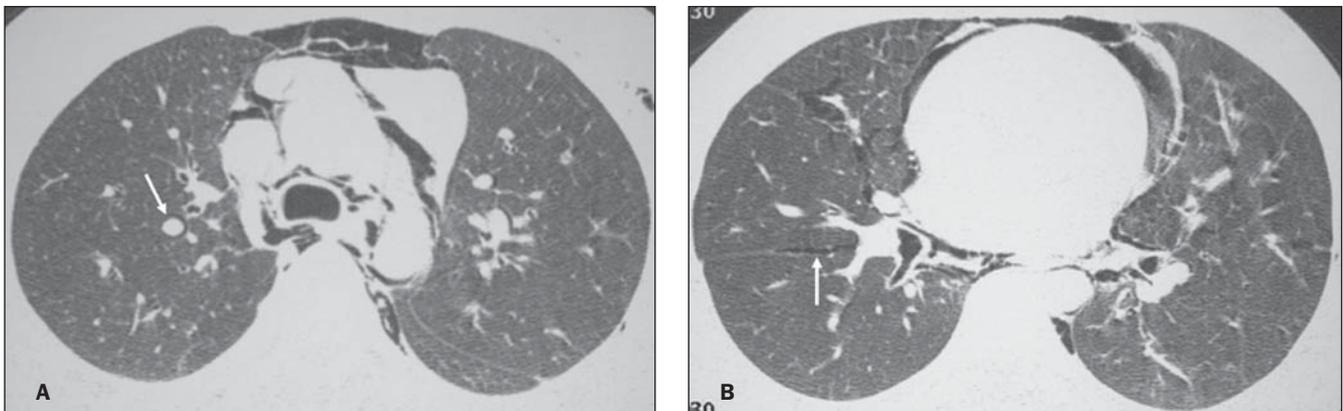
High resolution chest computed tomography at the level of the bronchial bifurcation (A) and upper cardiac region (B) demonstrating the presence of free air dissecting mediastinal structures, bronchi and pulmonary vessels (arrow on A). Also, observe the presence of small bilateral pneumothorax with air in the oblique fissure at right (arrow on B).
